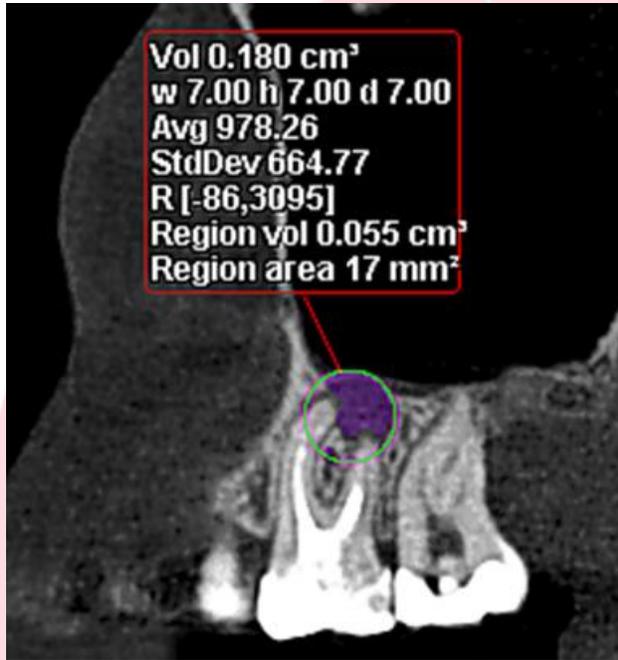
Sagittal CBCT slice shows chronic localized periodontitis at the apices of the vestibular roots of tooth 26 with a measured lesion volume – 0.055 cm³.
